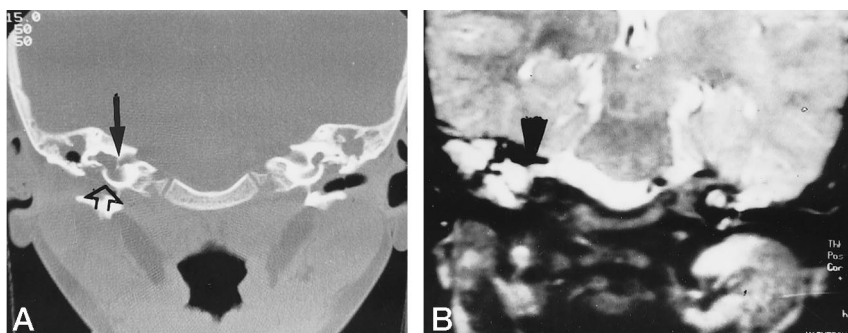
A, Plain high-resolution coronal CT section through the temporal bone reveals a bony defect at the lamina cribrosa of the right internal auditory canal (closed arrow). The vestibulocochlear complex is dysplastic and the cochlea is represented by a saclike diverticulum (open arrow).
